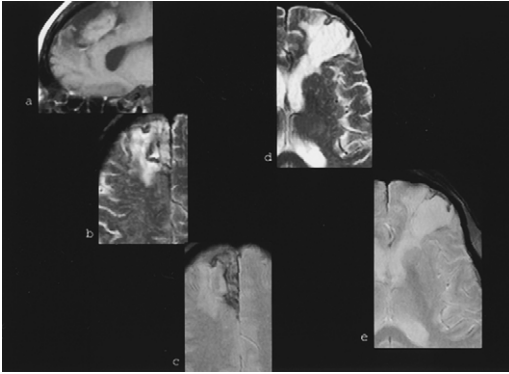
Amyloid angiopathy. Lobar hemorrhages of different ages in the frontal lobes. (a) High signal on the T1-weighted image because of persistent methemoglobin in the right frontal chronic hematoma 8 months after the event. (d,e) The dark hemosiderin rim around the encephalomalacia in the left frontal lobe is the only evidence of prior hemorrhage. (c,e) Note that hemosiderin is better demonstrated on the gradient-echo images.
